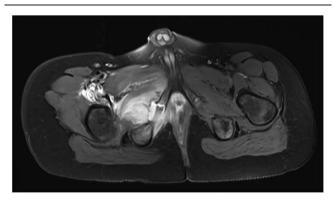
Axial T2 fat sat weighted magnetic resonance imaging (MRI) with enhancing rim within externus obturator, internus obturator, and levator ani muscle.
